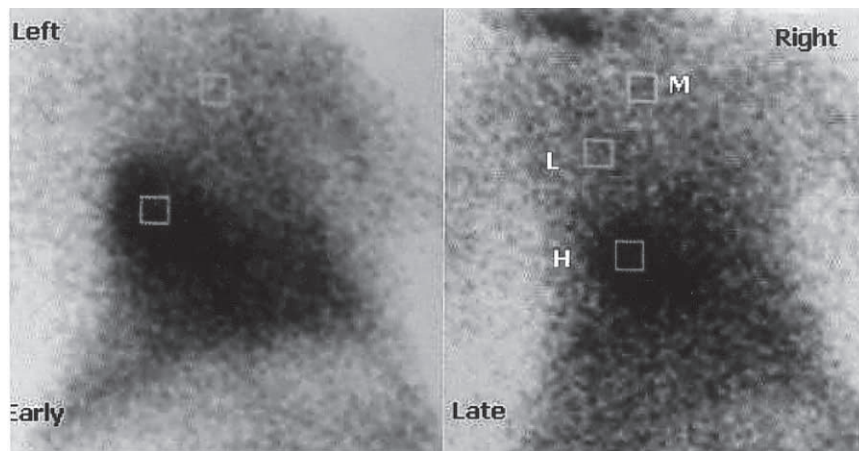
^{123}I -MIBG scintigraphy was shown at early (15 minutes) and late (3-hours) phases. Regions of interests from the heart (H), mediastinum (M) and lung area (L) were drawn.
